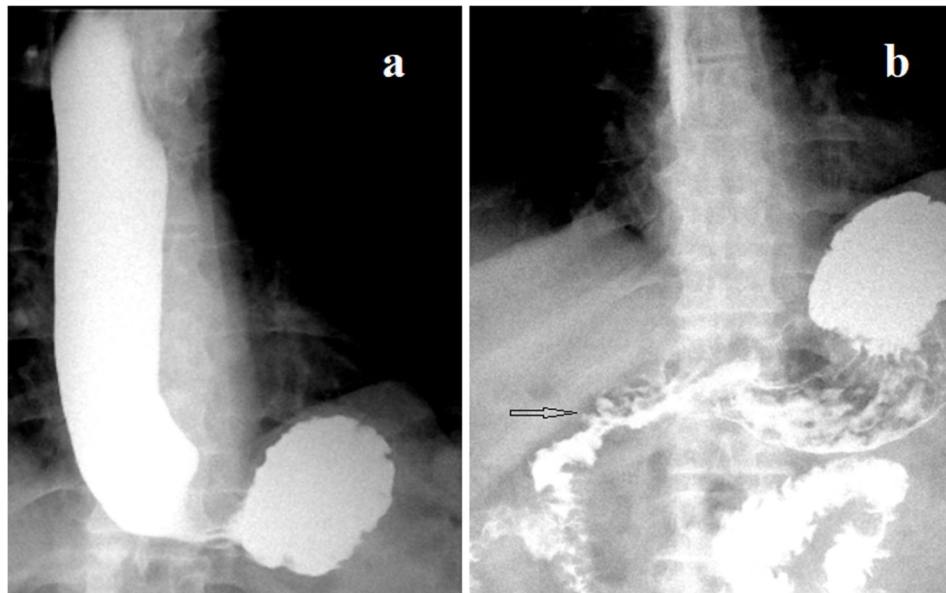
X-ray examination of esophagogastric junction during maximal provocation of high pressure in the stomach (Case 1). (a) The entire esophagus is dilated (3.8 cm instead of 1.5 cm) without peristalsis. The narrow segment between the esophagus and the stomach 1.4 cm long is a contracted LES, which is more than 2 times shorter than the minimum normal range. At the LES level, longitudinal folds are determined. (b) In a roentgenogram produced 3 minutes after the first one, barium is detected in the esophagus, which indicates impaired evacuation from the esophagus. Evacuation from the stomach is not impaired. The spasm and deformation of the duodenal bulb are determined. Suspicion of an ulcer in the bulb or in the pyloric canal (arrow). XIR is 2.71
